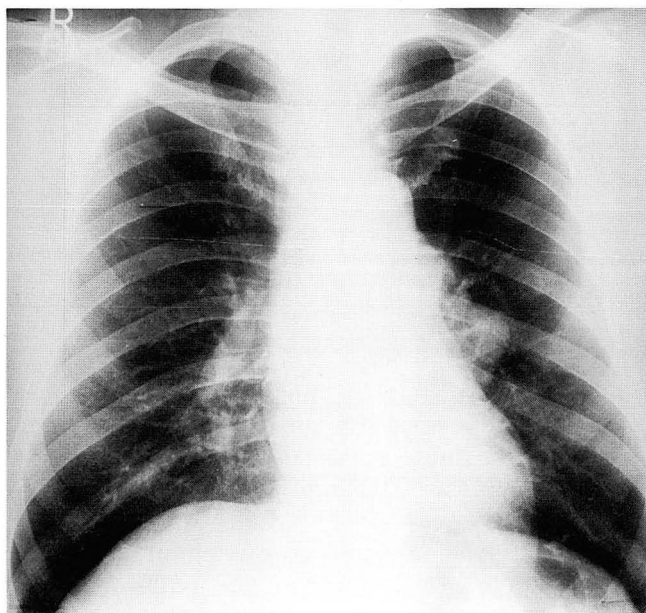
A 55-year-old man with amyloidosis involving the mediastinal and hilar lymph nodes. Chest radiograph shows soft tissue masses in the left hilar and infrahilar regions, and the AP window. (AP : aortopulmonary)
